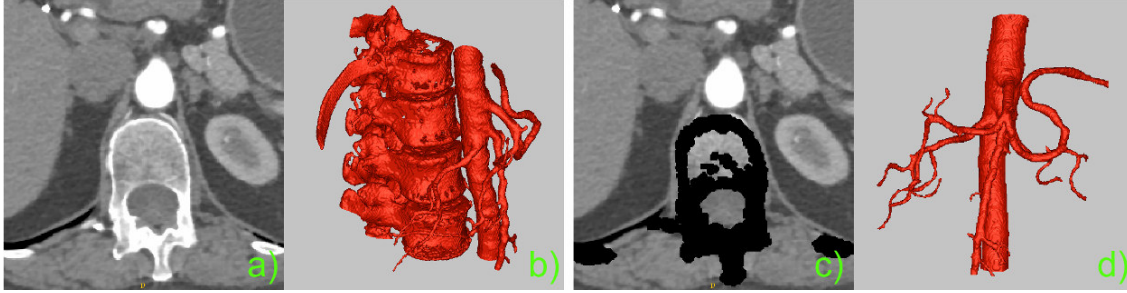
(a) CT slice of an arterial phase: lumbar arteries touching the spine and having the same density could compromise the segmentation, in fact the 3D model of the artery obtained directly from the dataset (c) includes the spine. (b) Removing pre-segmented bones from the dataset allows to correctly segment arterial branches (d).
